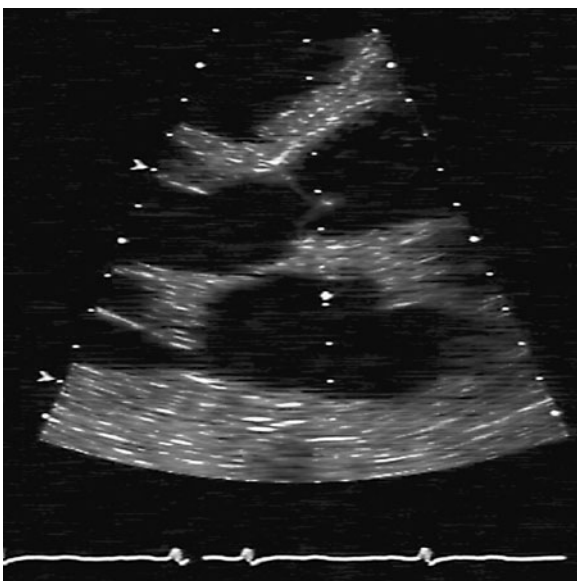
Long-axis echocardiogram of full root Freestyle valve. Note the nearly normal appearance of the root and leaflets with full opening of the outflow tract.
